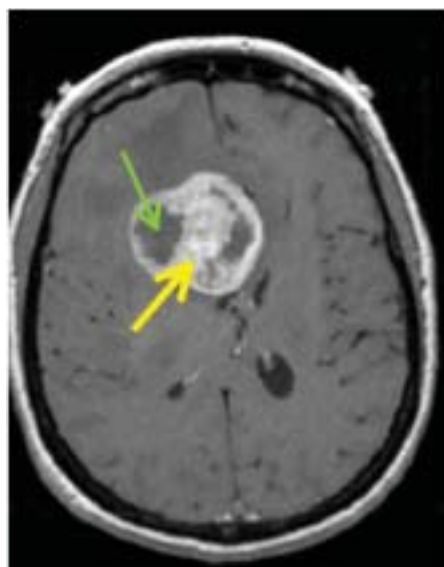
Contrast-enhanced MRI of a patient with GBM. Green arrow indicates an area within the tumor that is not enhancing (NE), yellow arrow indicates a contrast enhancing area (CE).
